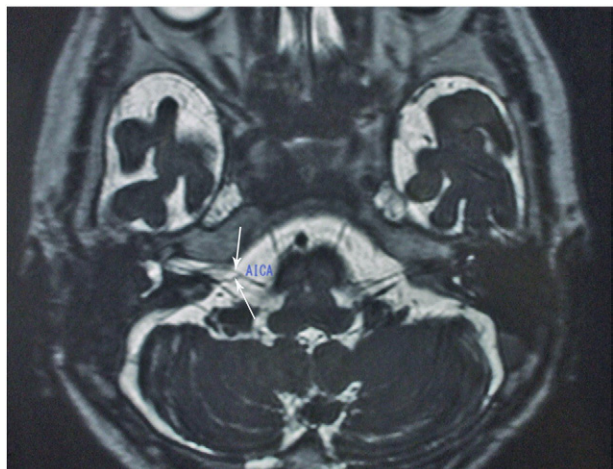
On 3D drive T2-weighted MRI, we can see the right IAA entering into the IAC with branching (type IB). We can see the bifurcated IAA in a 72-year-old woman with tinnitus (long white arrows).
